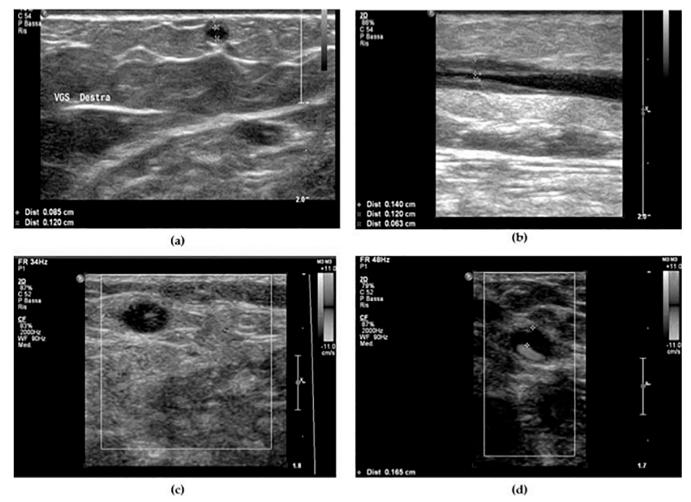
The figures show a hypoechoic cuff around the veins of the superficial venous system, suitable for vascular inflammatory lesions. The complete vein wall coaptation with compression by the transducer excludes the presence of thrombi. (a,b) B-mode image of the right great saphenous vein; (c,d) Colour-flow Doppler image of the right cephalic vein demonstrating a blood flow in the lumen.
